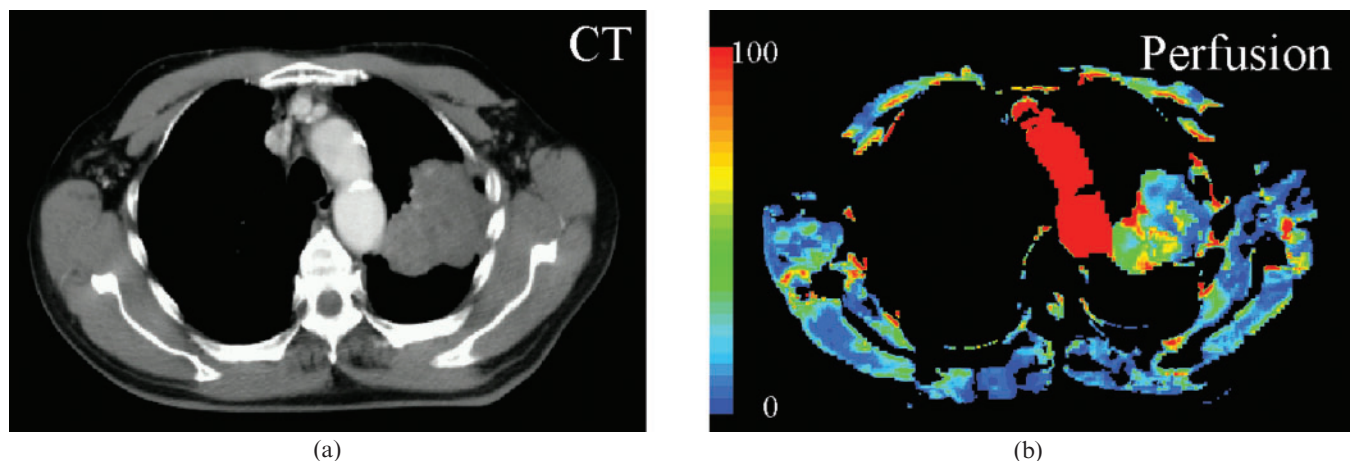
Perfusion CT of a lung nodule obtained using the deconvolution method. (a) CT image, (b) perfusion image. Note the heterogeneous distribution of perfusion within the nodule.
